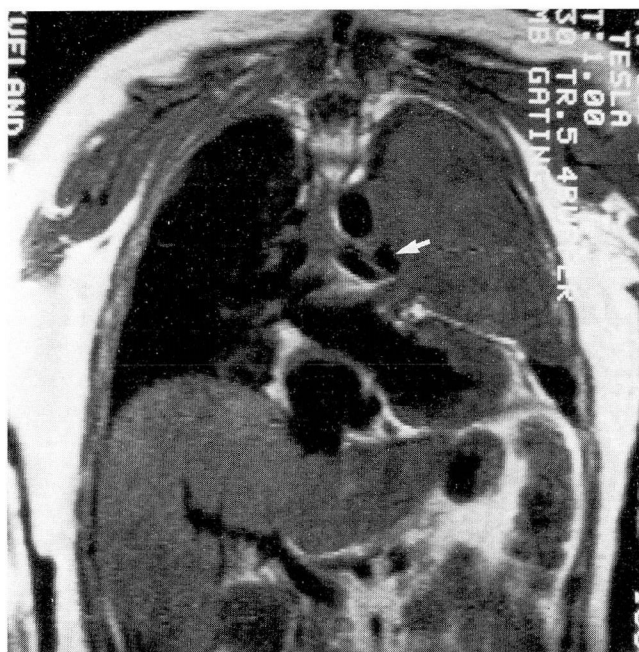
Malignant fibrous histiocytoma. Coronal magnetic resonance image, TE 30/TR 500, shows compression of the left pulmonary artery (arrow) by a soft-tissue mass occupying the left hemithorax.
